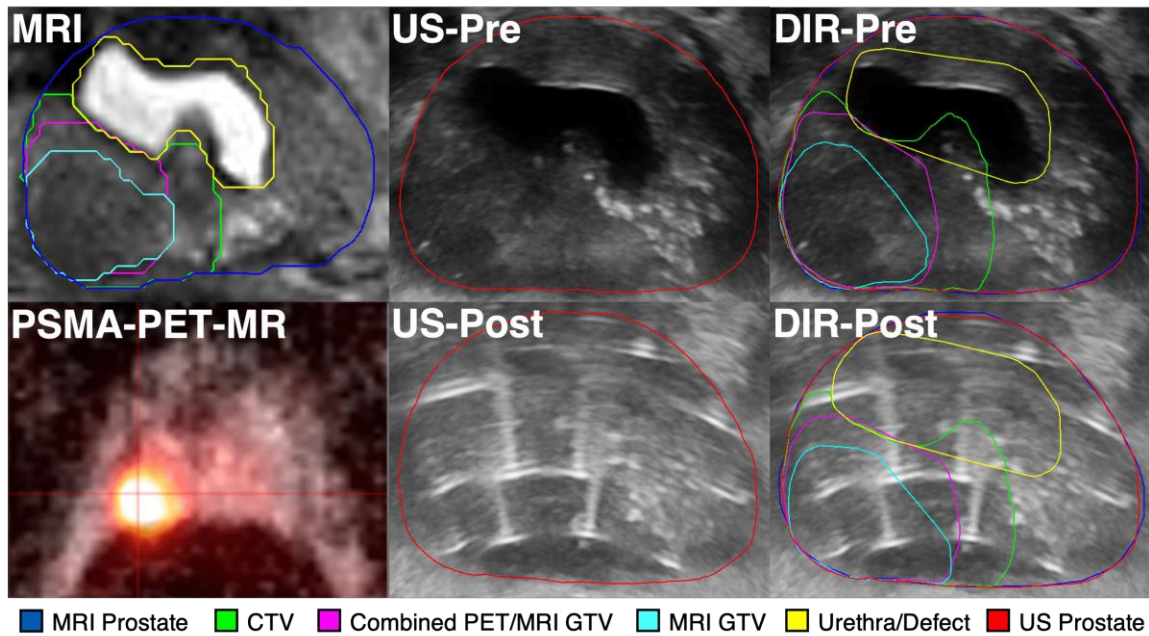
Example intraoperative clinical registration results in a prospective clinical case. The physician-contoured MR image is shown in the top left pane. The pre- and post-implant US image and registration results generated using our DIR algorithm are shown in the top and bottom row, respectively. The contour legend is provided in the bottom left pane.
